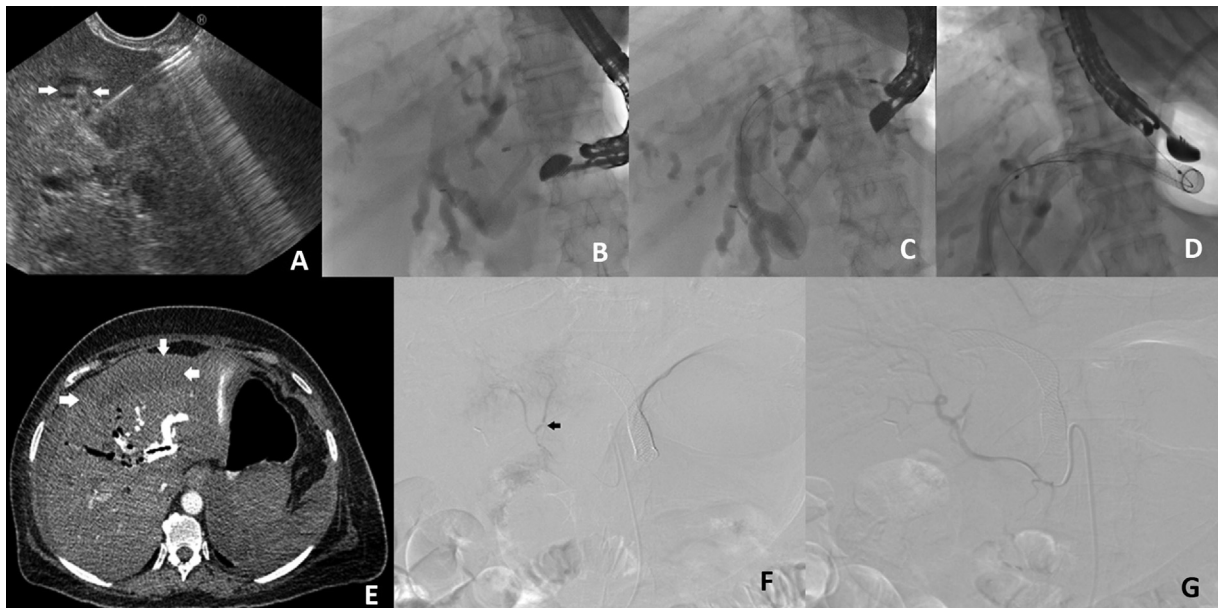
Fatal bleeding after endoscopic ultrasound-guided hepaticogastrostomy (EUS HGS). (A) EUS: Immediately after puncturing the bile duct, extravasation of echogenic contents (arrow) noted in the dilated biliary system. The aspirated bile was found to be hemorrhagic. (B) The needle track was dilated and cystotome negotiated into dilated biliary radicles. However, guide wire could not be negotiated deep into the biliary system. (C) Second attempt for EUS HGS. The segment 2 liver punctured through the stomach. The guide wire negotiated deep into common bile duct and the tract dilated with 6Fr cystotome. (D) Fully covered metallic self-expanding metallic stents (80 × 10mm) inserted into the left ductal system. (E) Computed tomography abdomen: Large subcapsular hematoma (arrows) with pneumobilia. (F) Digital subtraction angiography: Selective cannulation of left hepatic artery (arrow) and prophylactic Gelfoam and polyvinyl alcohol embolization. (G) Digital subtraction angiography: Post-left hepatic artery embolization.
